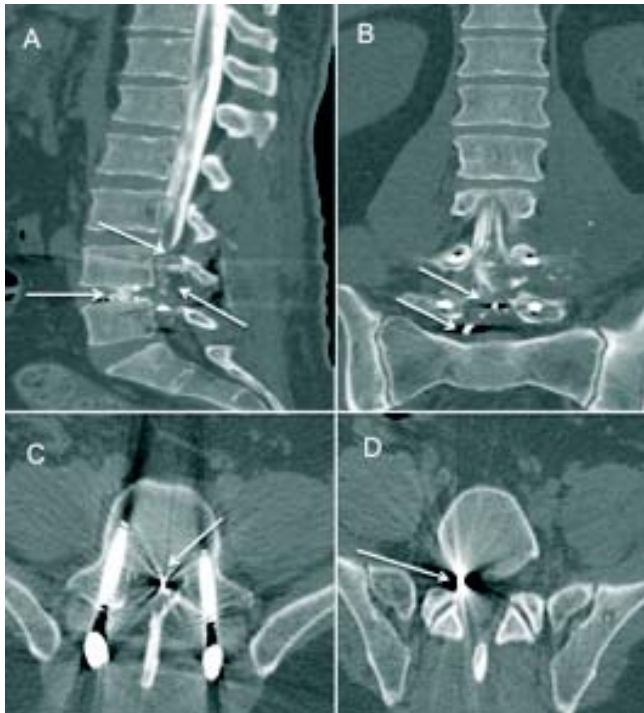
Postoperative CT-myelography with multiplanar reconstructions. A. Sagittal plane image shows the interruption of the CSF containing contrast and the presence of splinters the intervertebral level L4-L5 (white arrows). B. Coronal plane showed two residual splinters from the handgun at the L5 lumbar canal (white arrows). C and D. Axial plane at the level of L5-S1 showing metallic rods (thick arrows) together with presence of the two previously seen splinters, this plane evidence location of splinters in the lumbar spinal canal and at the entrance of right intervertebral foramen.
